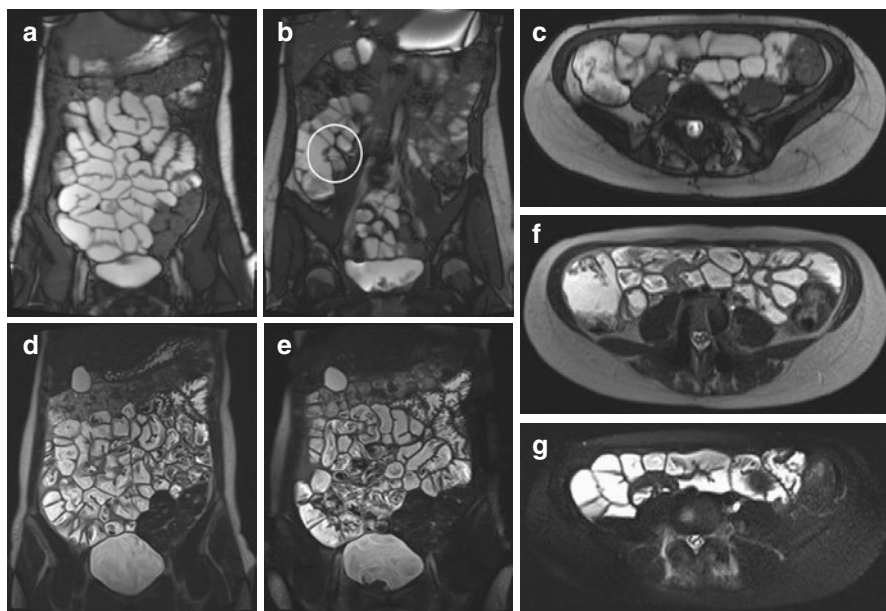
MRI sequences in a standard MRE protocol; (a, b) Coronal steady-state free precession gradient echo (SSFP/Trufi) with good terminal ileum (white circle) distention. (c) Axial T2 Trufi. (d, e) Coronal and (f, g) axial T2 half-Fourier single-shot fast echo (HASTE) sequences with/without fat saturation, respectively
